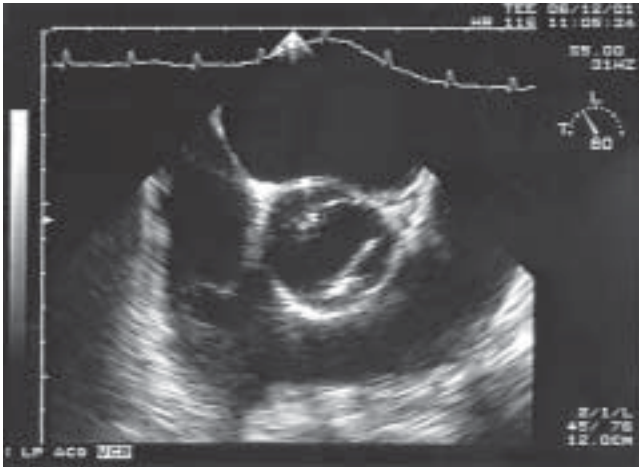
Still figure from transesophageal echocardiogram in systole showing partially opened bicuspid aortic valve (center). Note the moderate calcification of the valve leaflets given the patient's relatively young age.
